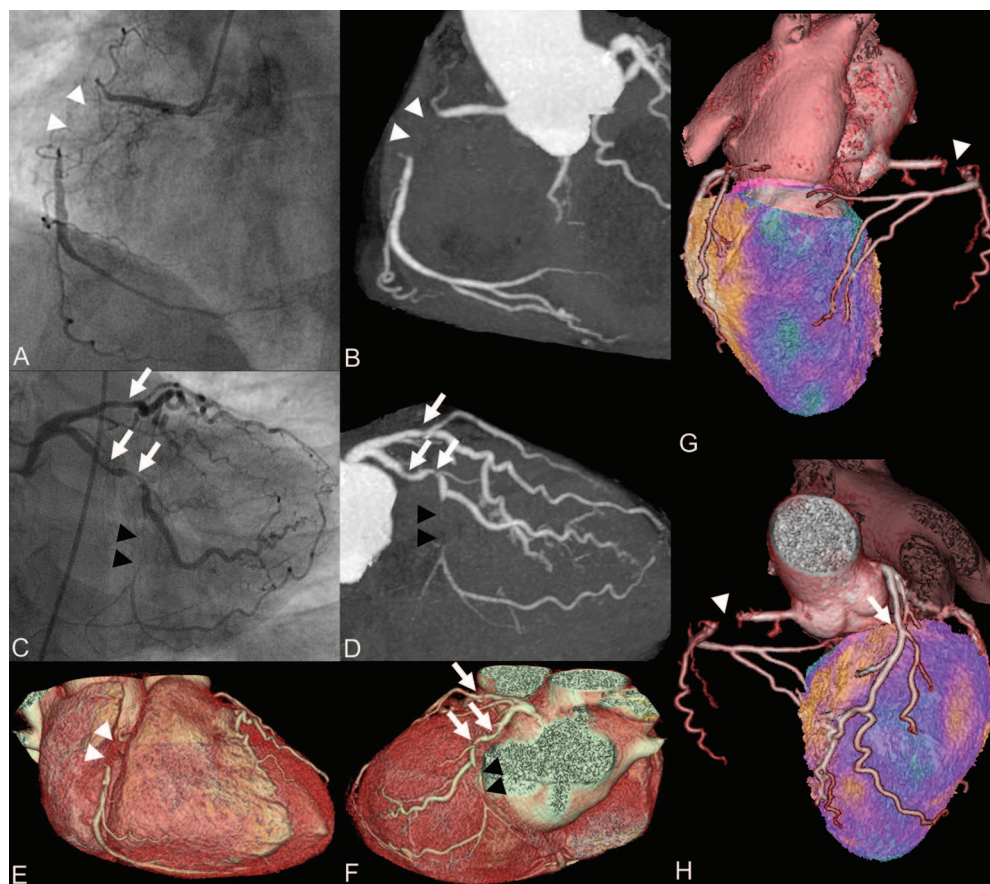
Images A-H reveal total occlusions of the right coronary artery (white arrowheads) and the distal circumflex artery (black arrowheads) with retrograde filling of the vessels (A and C: catheter angiography, B and D: computed tomography coronary angiography (CTCA) maximum intensity projections, E and F: volume rendered CTCA, G and H: fused positron emission tomography, PET/CTCA images). Additionally, 2 sequential significant stenoses are demonstrated proximal to the total occlusion in the circumflex artery and 1 significant stenosis is documented in the proximal left anterior descending artery (white arrows). Noninvasive assessment of viability was performed by F-18 FDG PET (Advance, GE Healthcare) and fused with a CTCA to identify culprit lesions with their respective territory as previously reported.¹⁻³ CTCA was performed with a Light-Speed VCT XT scanner (GE Healthcare) using prospective gating with "SnapShot Pulse" technology^{4,5}; the smallest x-ray window was chosen (only 75% of the RR-cycle); tube current was 550 mA; tube voltage was 100 kV. The patient had a mean heart rate of 54 bpm, her body mass index was 25.6 kg/m²; the applied radiation dose of CTCA was 1.2 mSv (as estimated from the dose length product: 71.6 mGycm). Fused PET/CTCA images (G and H) demonstrated a large scar in the inferior myocardium, corresponding to the total occlusion in the right coronary artery, and infarcted scar tissue with partially preserved viability in the anterior myocardium, corresponding to the presumably recanalized lesion in the left anterior descending artery. The lateral myocardium was viable, despite the total occlusion in the distal circumflex artery, most probably due to collaterals, which lead to retrograde filling of the vessel.
